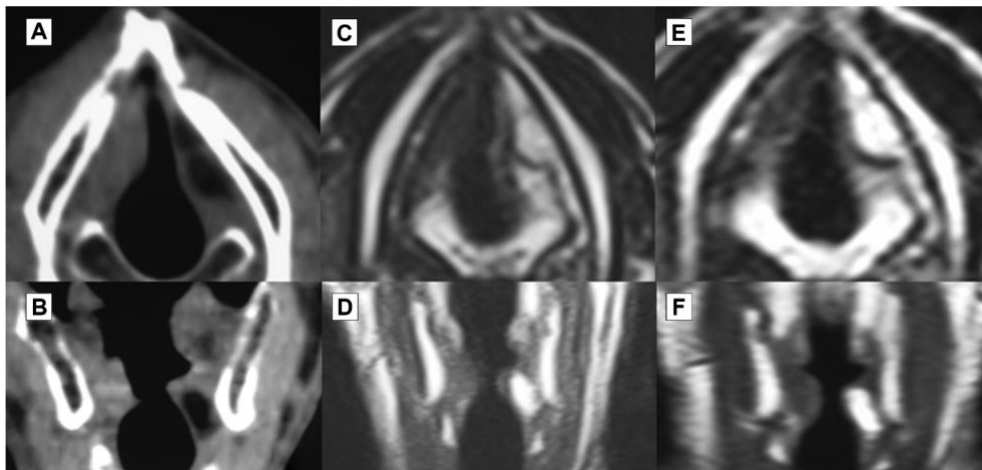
Long-term CT and MRI images following fat injection
